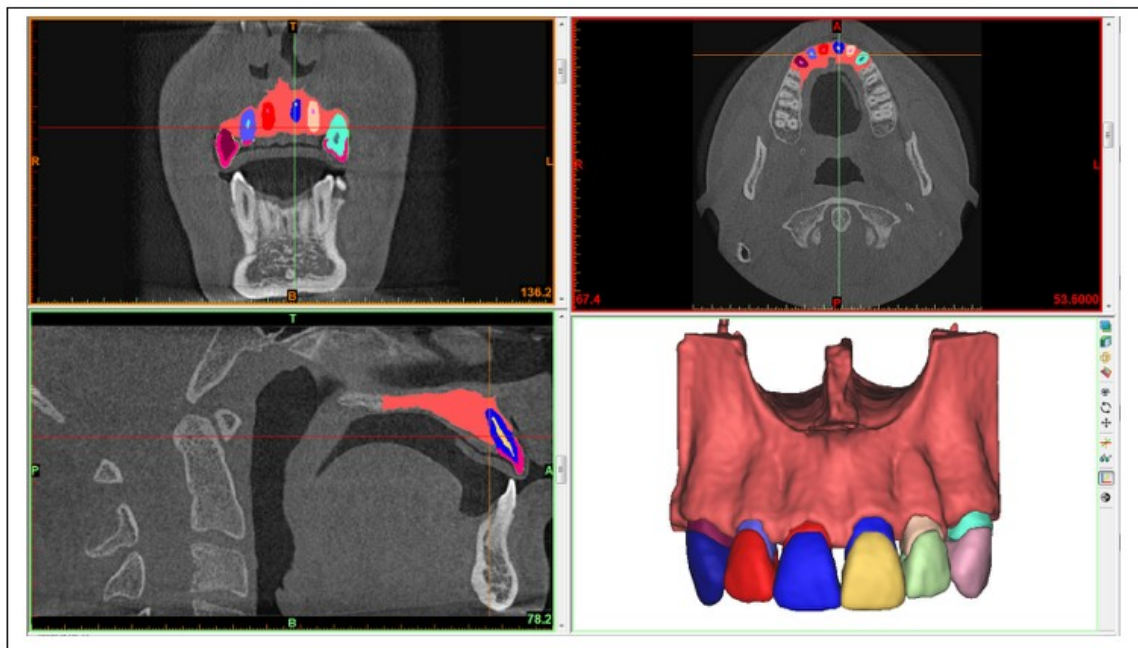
Segmentation of teeth, soft tissues and bone structures obtained by cone-beam tomography using Mimics software (Materialise).
